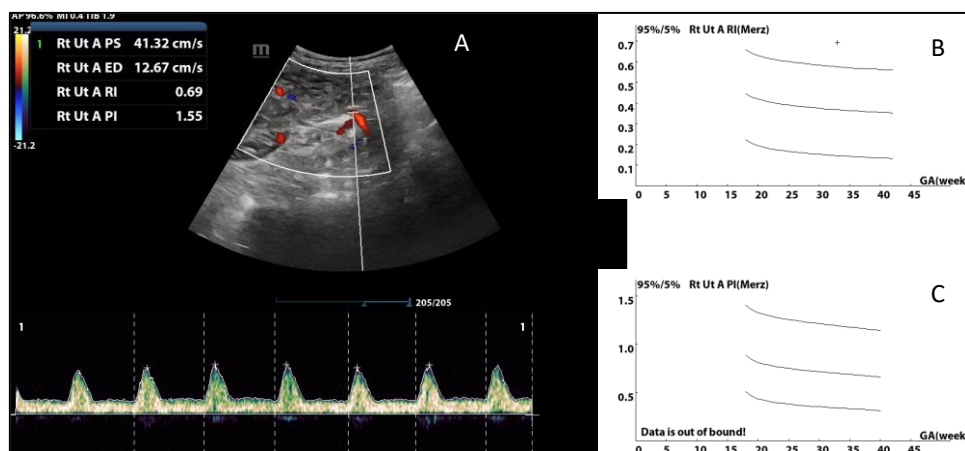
Right uterine artery color and spectral Doppler [A], showing early diastolic notching, [B], high uterine artery resistance index [RI-0.69] above 95<sup>th</sup> percentile and C]. very high pulsatility index [PI-1.55] above 95<sup>th</sup> percentile and beyond the limit of 1.5
